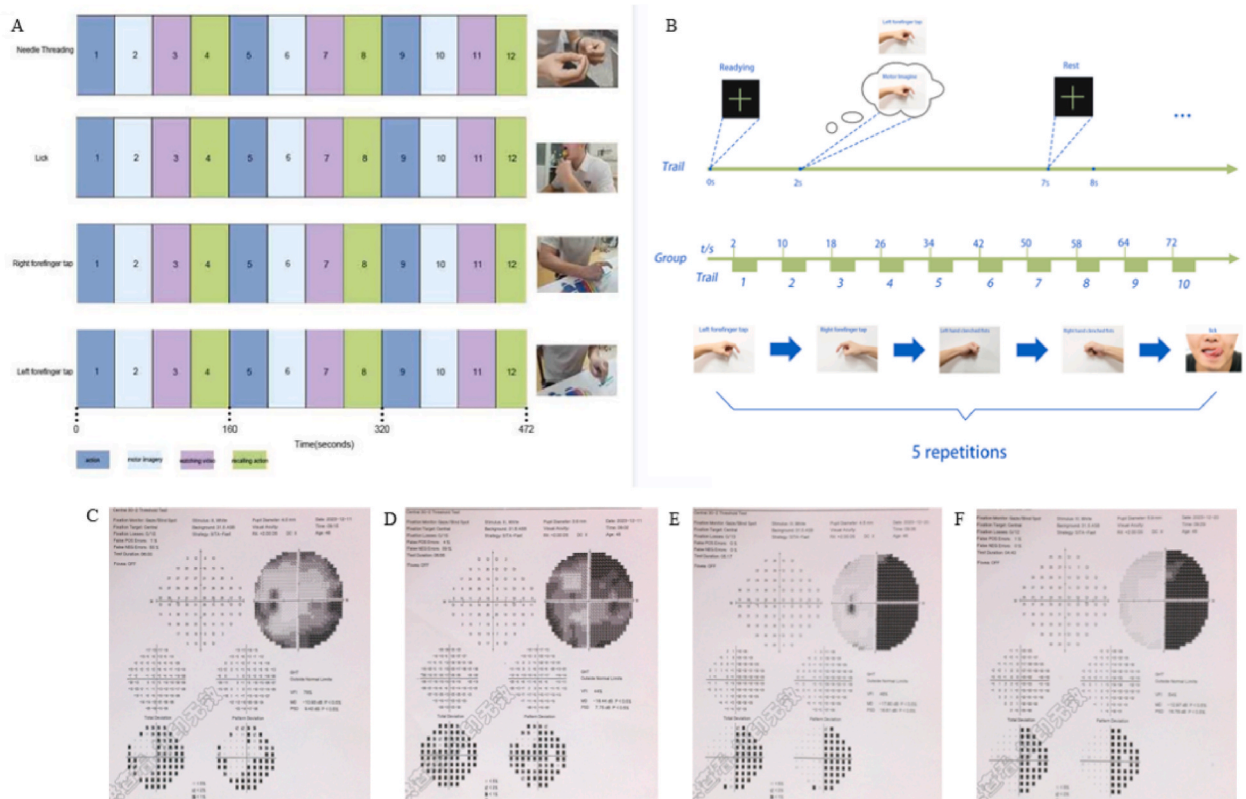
Experimental Paradigm and comparison of binocular vision before and after surgery: Panel A represents the preoperative task-state functional MRI experimental paradigm, while Panel B depicts the intraoperative ECoG experimental setup. Panels C and D provide visual field tests for the left and right eyes before surgery, respectively. Panels E and F display the postoperative visual fields, demonstrating the visual changes after the occipital lobe tumor resection.
